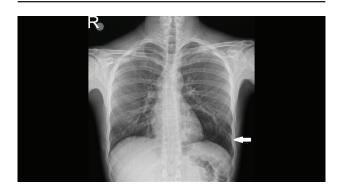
Chest X-ray taken at an external center showed an emphysematous area in the left lower zone.
